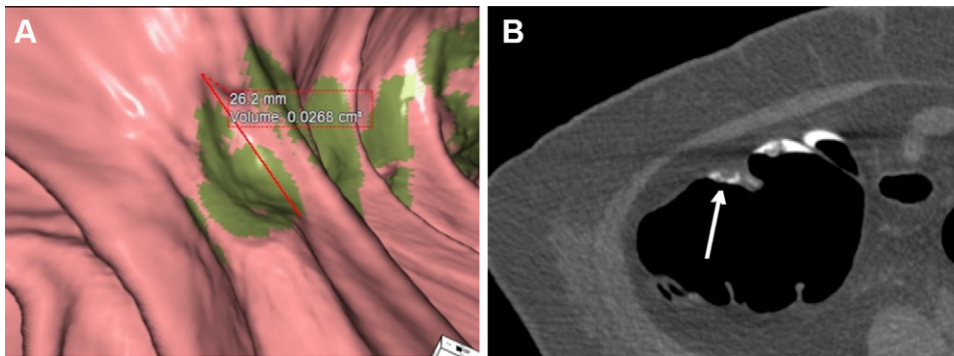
Flat lesion. A 70-year-old male patient who underwent diagnostic CT colonography for anemia was found to have a flat lesion (arrow in B) coated with iodinated contrast material along a haustral fold in the ascending colon on (A) three-dimensional endoluminal view and (B) axial prone view. This was determined to be a tubular adenoma at polypectomy.
